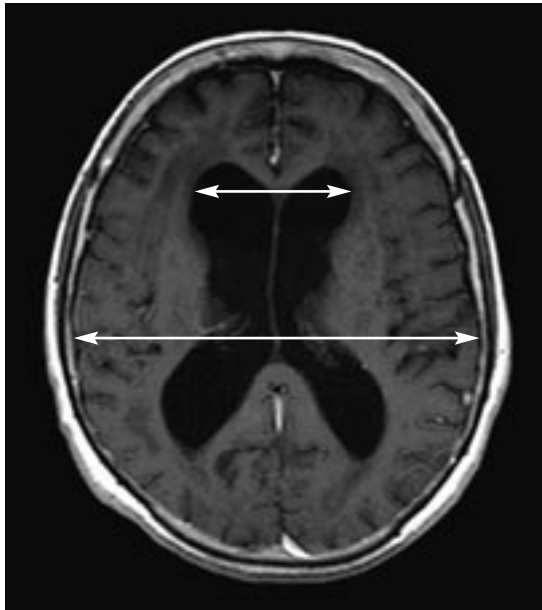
Magnetic resonance image showing ventriculomegaly in a patient with normal pressure hydrocephalus. The Evans ratio is the maximum width of the anterior horns (shorter arrow) divided by the maximum width of the calvarium (longer arrow). Hydrocephalus is defined by a ratio of 0.3 or greater; this patient's ratio is 0.4.
